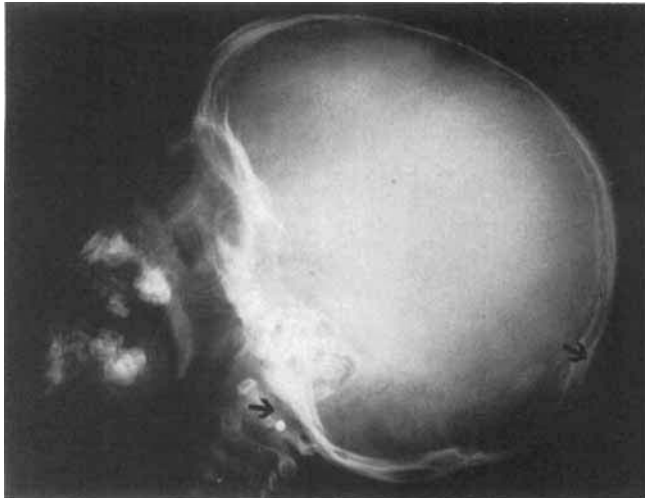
Left lateral skull roentgenogram. Arrows indicate position of exostoses. Note inward denting of skull in parietal area.
